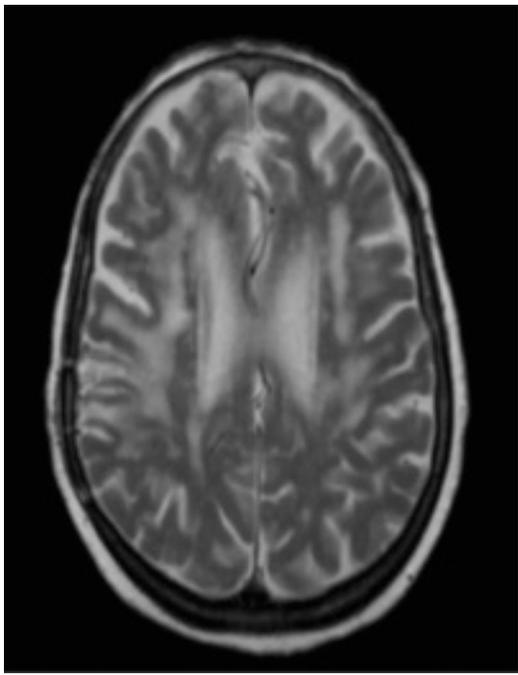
Brain MRI. T2-weighted sequence. Significant decreases in the volumes of lesions and associated oedemas after 4 months of CTx treatment.
